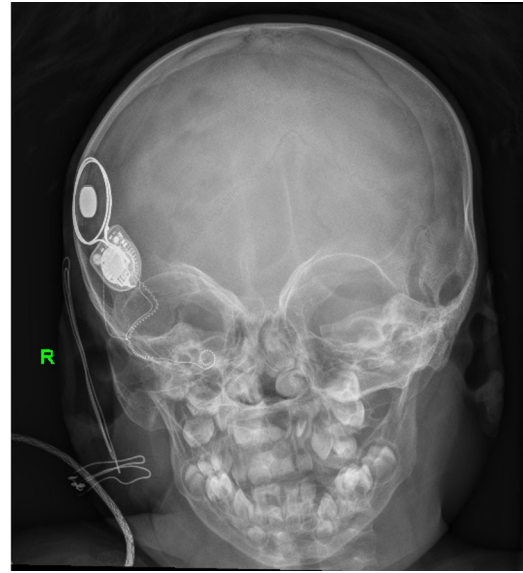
Fully inserted cochlear implant is shown by transorbital X-ray.
